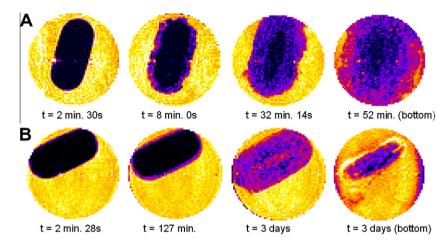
MRI 2D slice selection of tablet center (axial view) as a function of time for fosamprenavir tablets in USP SGF (A) and the nutritional drink Scandishake Mix[®] (B). Yellow indicates highly mobile proton intensity, while black indicates no-mobile proton intensity. The images at the right hand side (bottom 2D slices) show complete tablet disintegration in SGF (A) versus swelling but no disintegration in the nutritional drink (B).
